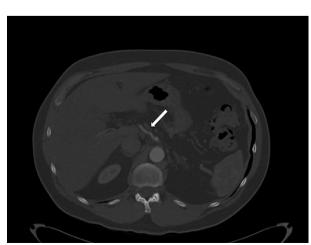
3 month follow-up CTA showing patent hepatic artery.
